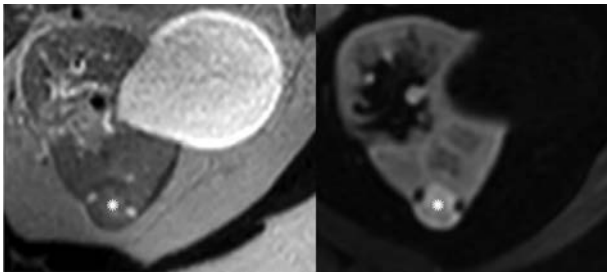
MRI in RCC. (A) Axial slices from renal protocol MR: (a) T2w and (b) postcontrast T1w in a young patient with Birt-Hogg-Dubé syndrome and previous bilateral chromophobe RCCs. Asterisks indicate an enhancing solid-cystic lesion in the posterior cortex of the left kidney. A simple cyst is seen anterior to this.
